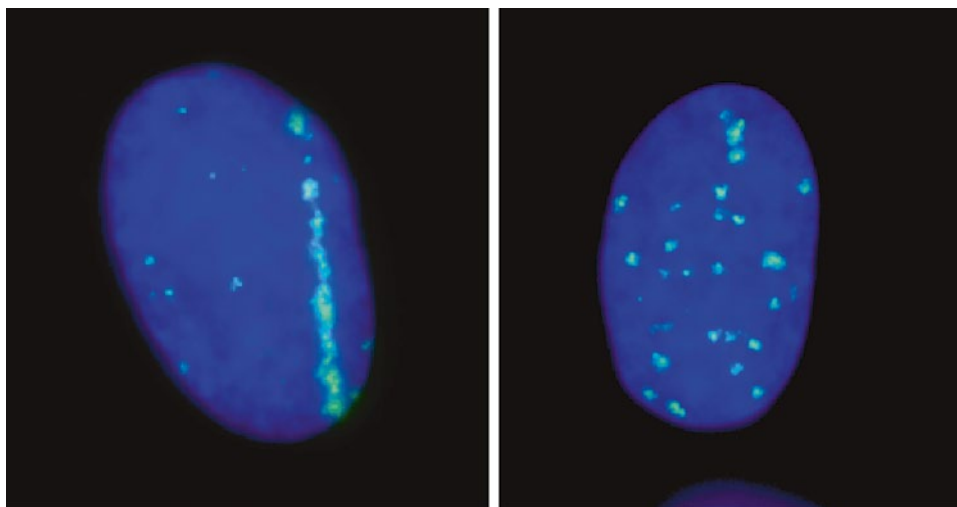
Biological track structure of heavy-ion traversal in cell nuclei. DNA double-strand breaks were visualized after very high-LET horizontal iron-ion beam (*left*) and X-rays (*right*). Clear structure after iron beam traversal was observed, but no such structure for X-rays
